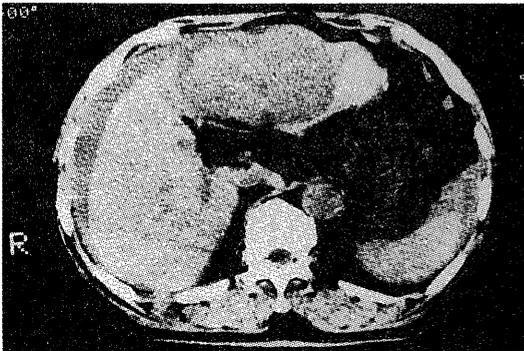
CT imaging of Case 4 demonstrating subcapsular rupture of HCC in left lobe.
